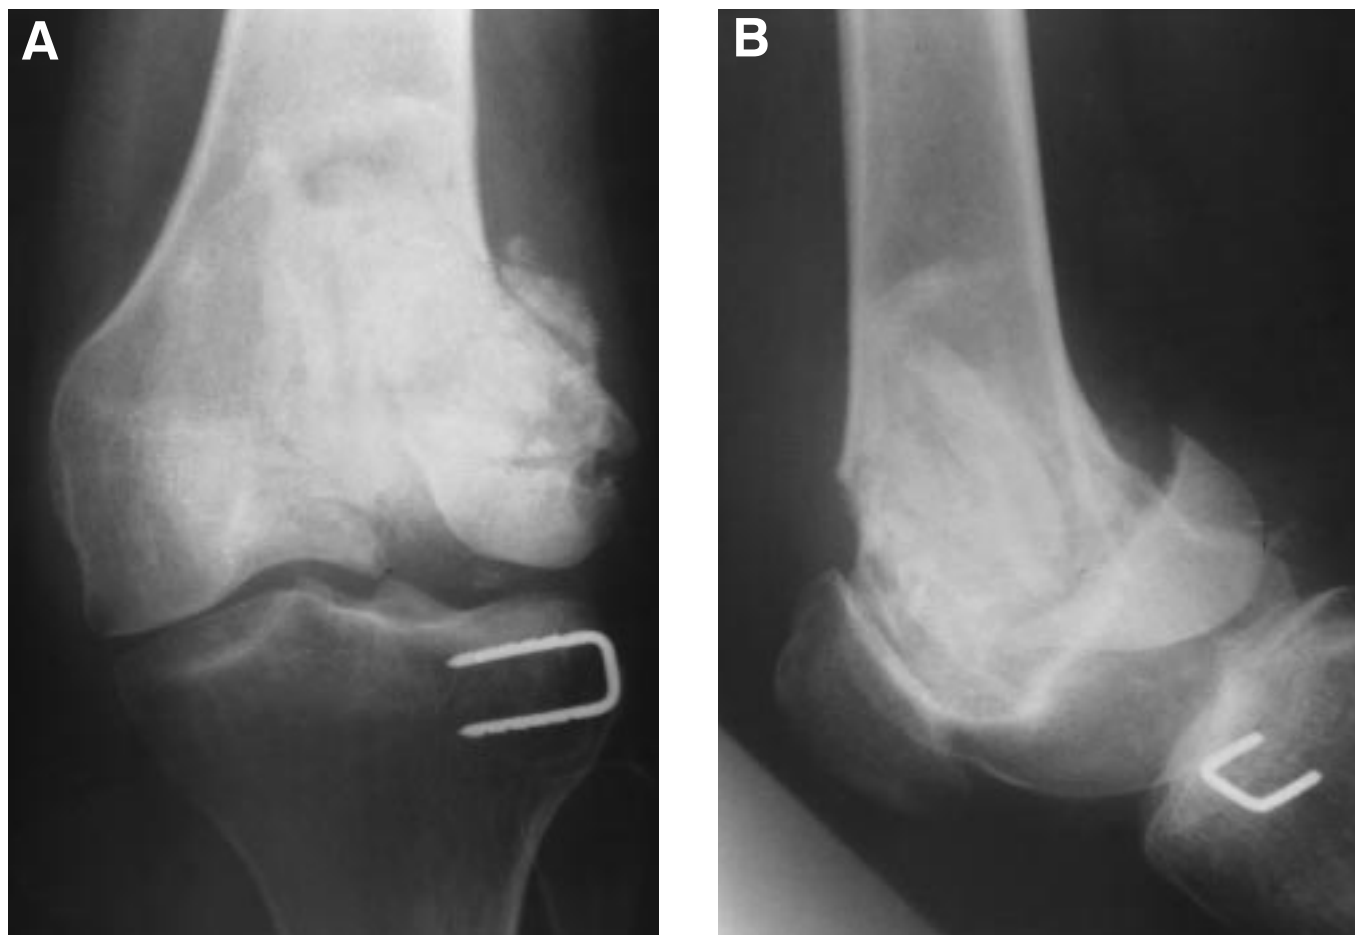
Plain radiographs of the distal femur: (A) anteroposterior, and (B) lateral views, showing a pathologic fracture of the lateral femoral condyle. The fracture occurred 18 months following cryosurgery, in which internal fixation was not used for reconstruction. Reinforcement of the tumor cavity with PMMA and internal fixation is strongly recommended in all cases.
